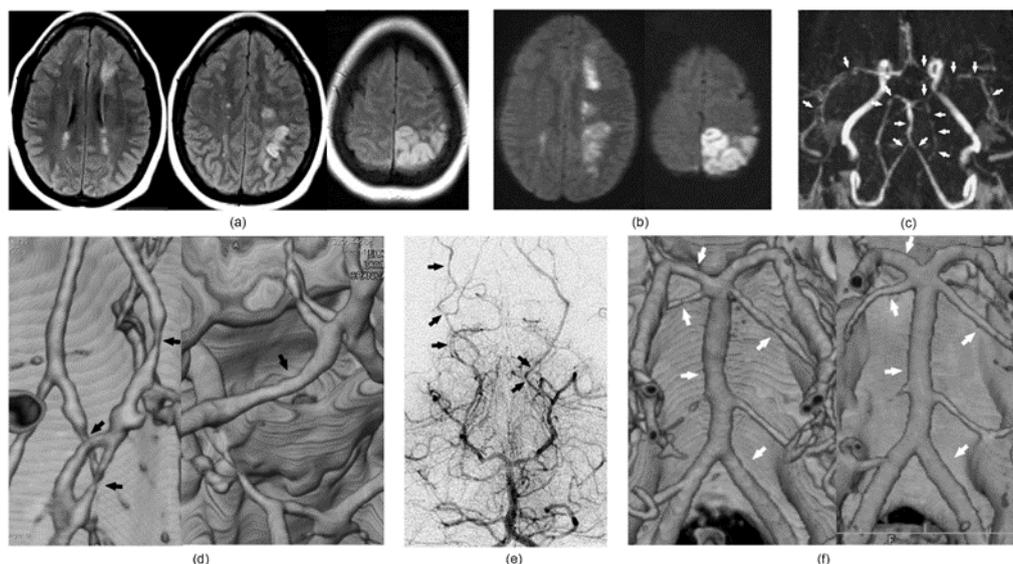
(a-f). Reversible cerebral vasoconstrictive syndrome. (a) MRI FLAIR imaging on presentation demonstrates multifocal abnormal hyperintense signal within the bilateral hemispheric white matter, more prominent in the parietal and occipital lobes where it extends to the cortex. (b) T2-diffusion imaging demonstrates restricted diffusion consistent with acute ischemia. The white matter distribution within the left hemisphere straddles the anterior, middle and posterior cerebral vascular territories, a ‘watershed’ distribution. (c) MRA at admission demonstrates short segment multifocal narrowing within the distal bilateral vertebral arteries, the basilar artery, and bilateral middle and posterior cerebral vasculature (white arrows). (d) CTA demonstrates moderate narrowing within the right PCA P2 segment and a more severe narrowing distally within the P3 parieto-occipital segment (left, black arrows). Mild narrowing is present within the ACA A1 segment (right, black arrow). (e) CA confirms multifocal narrowing within the bilateral posterior cerebral arteries (black arrows). (f) Follow up CTA (at presentation on the left, 5 months follow-up on the right) reveals complete resolution of the original findings. Abbreviations: MRI, magnetic resonance imaging; FLAIR, fluid attenuation inversion recovery; MRA, magnetic resonance angiography; CTA, computed tomographic angiography; PCA, posterior cerebral artery; CA, catheter angiography; ACA, anterior cerebral artery. Courtesy of Adam Davis, MD.
